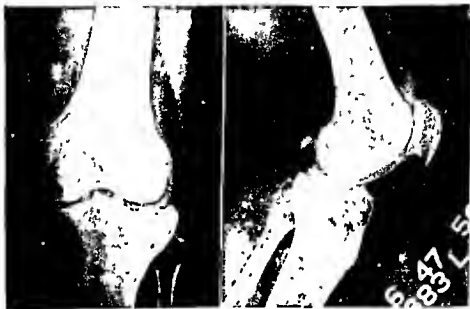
X-ray views taken two years after injury revealed a healed fracture of the lateral condyle of the left tibia with depression of this table level. The joint interval in the lateral half was increased due to the depression of the tibial table but the level of the femoral condyles was maintained and the alignment of the tibial and femoral shafts showed only slight varus deformity.
